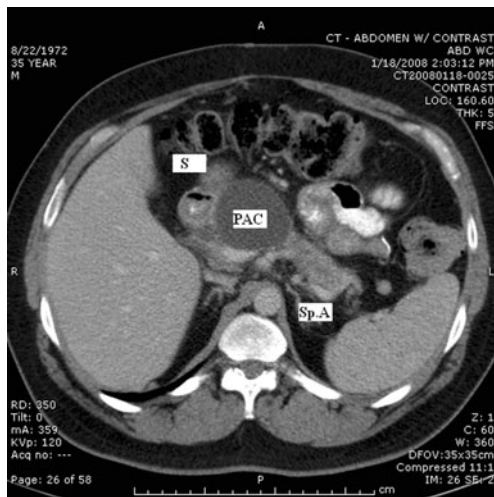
Preoperative CT scan with PO and IV contrast. The pancreatic pseudocyst (PAC) is in close relationship with the posterior gastric wall (S); there is no splenic artery (SpA) interposition.
